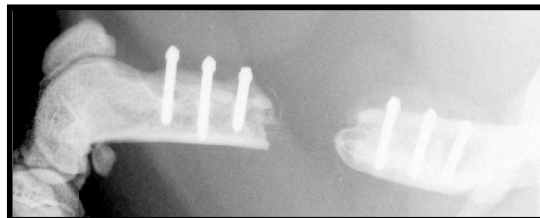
High resolution x-ray imaging of the healing femora
